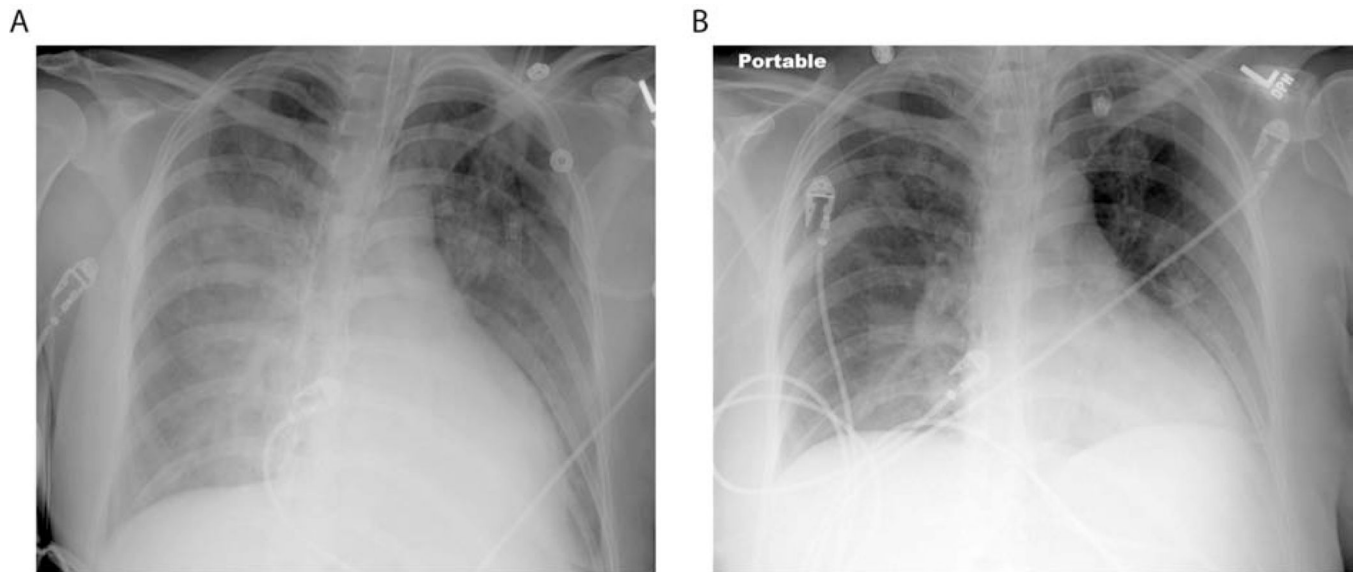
Resolution of ARDS. Typical chest radiography findings in a patient with ARDS include patchy bilateral airspace opacities (A). During resolution, these changes improve significantly (B).
